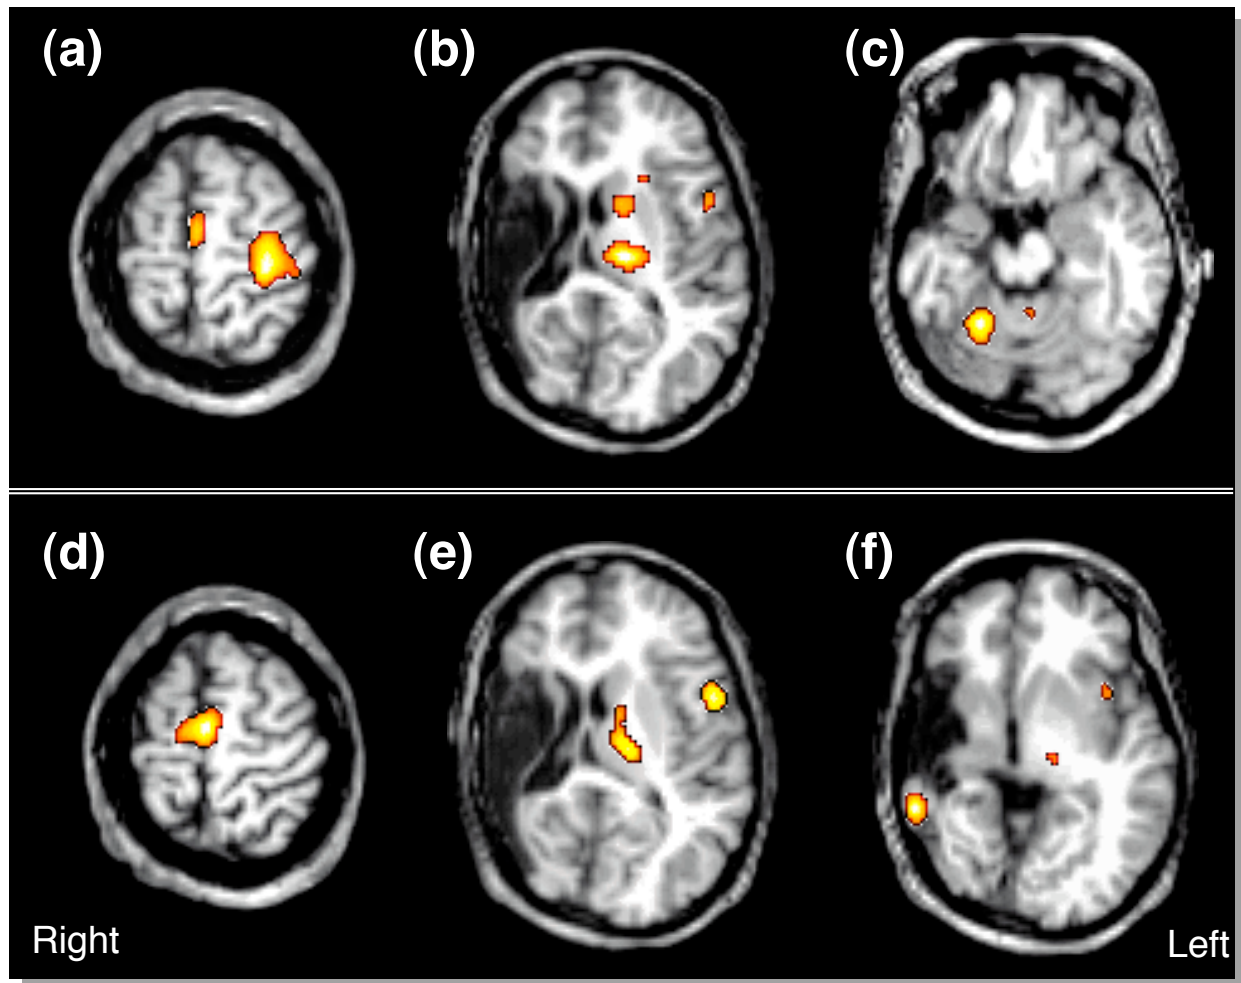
Regional cerebral blood flow (rCBF) increases $> 20\%$ ($p < .001$; uncorr.) for unilateral finger movement in a 20-year-old patient with history of intrauterine or perinatal middle cerebral artery infarction in the right hemisphere (from Müller *et al.*, 1998g). The activations from the [^{15}O]-water PET subtraction images are superimposed onto the patient's structural MRI. In the upper row, a normal pattern of activations for finger movement of the unaffected right hand is seen in primary motor cortex and the supplementary motor area (a), as well as in the thalamus, basal ganglia, and premotor cortex of the left hemisphere (b), and in the right anterior cerebellum (c). The lower row shows activations for movement of the hemiparetic left hand. Activations in the supplementary motor area (d) are enhanced and more bilateral compared to movement of the unaffected hand, but there is no activation in primary motor cortex. Atypical activations are also seen in the hemisphere *ipsilateral* to the side of movement in premotor cortex and in the thalamus (e). Finally, an unexpected activation is found in residual temporal cortex of the lesioned hemisphere (f). The activations for movement of the hemiparetic hand suggest that multiple regions are involved in reorganization, with the *exception* of the primary motor cortex.
